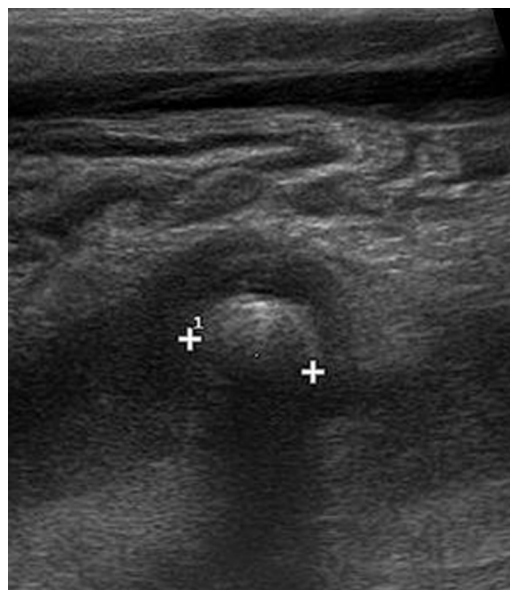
Ultrasonographic rounded image into the appendix referable to a coprolith.
